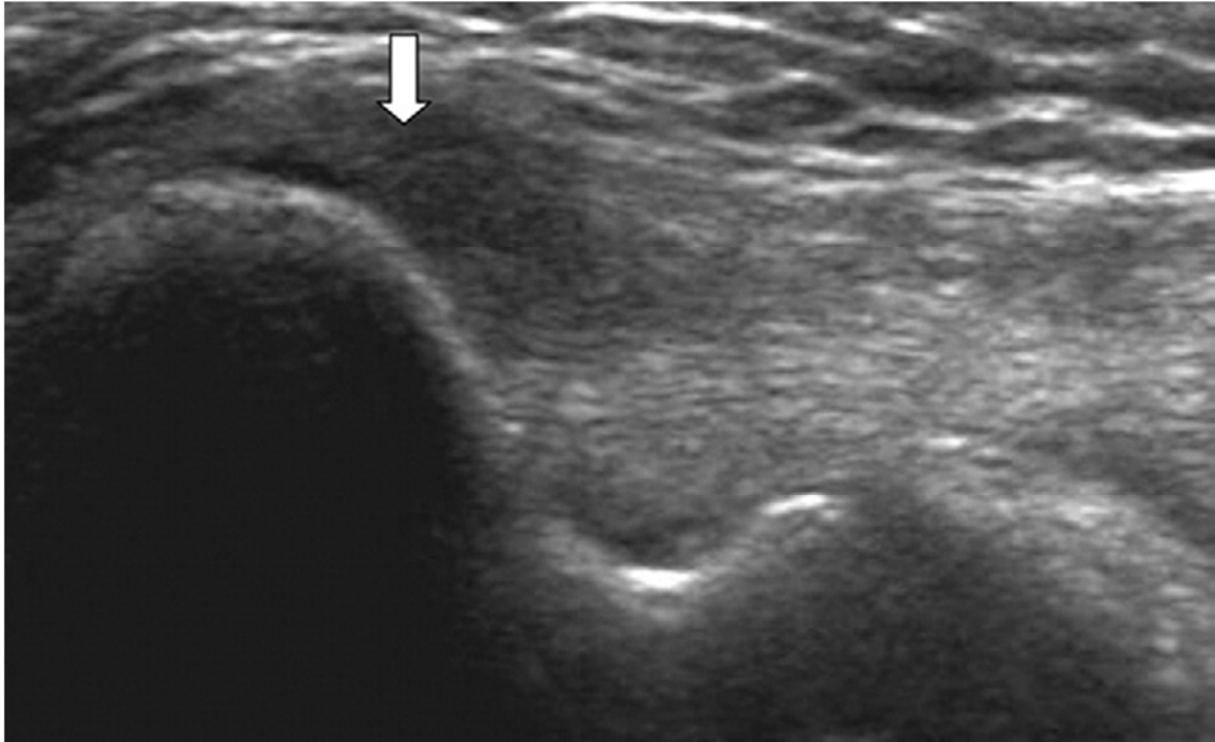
A longitudinal ultrasonographic image of the common flexor tendon of the left elbow in a 56-year-old woman with medial epicondylitis. The tendon had a focal hypoechoic area (arrow) that was consistent with tendinosis.(95)
